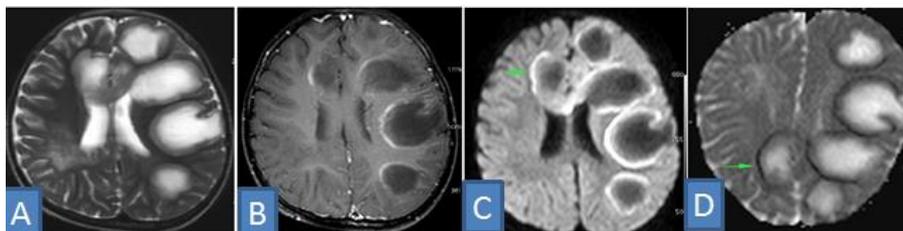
A case of Tumefactive Demyelination showing multiple well defined lesions in the subcortical white matter appearing hypointense peripherally with central hyperintensity on T2WI (A), showing “Open Ring” Enhancement of the active margins of the plaques on post contrast images (B), with restriction of margins on DWI (C) with low ADC values on ADC (D).
